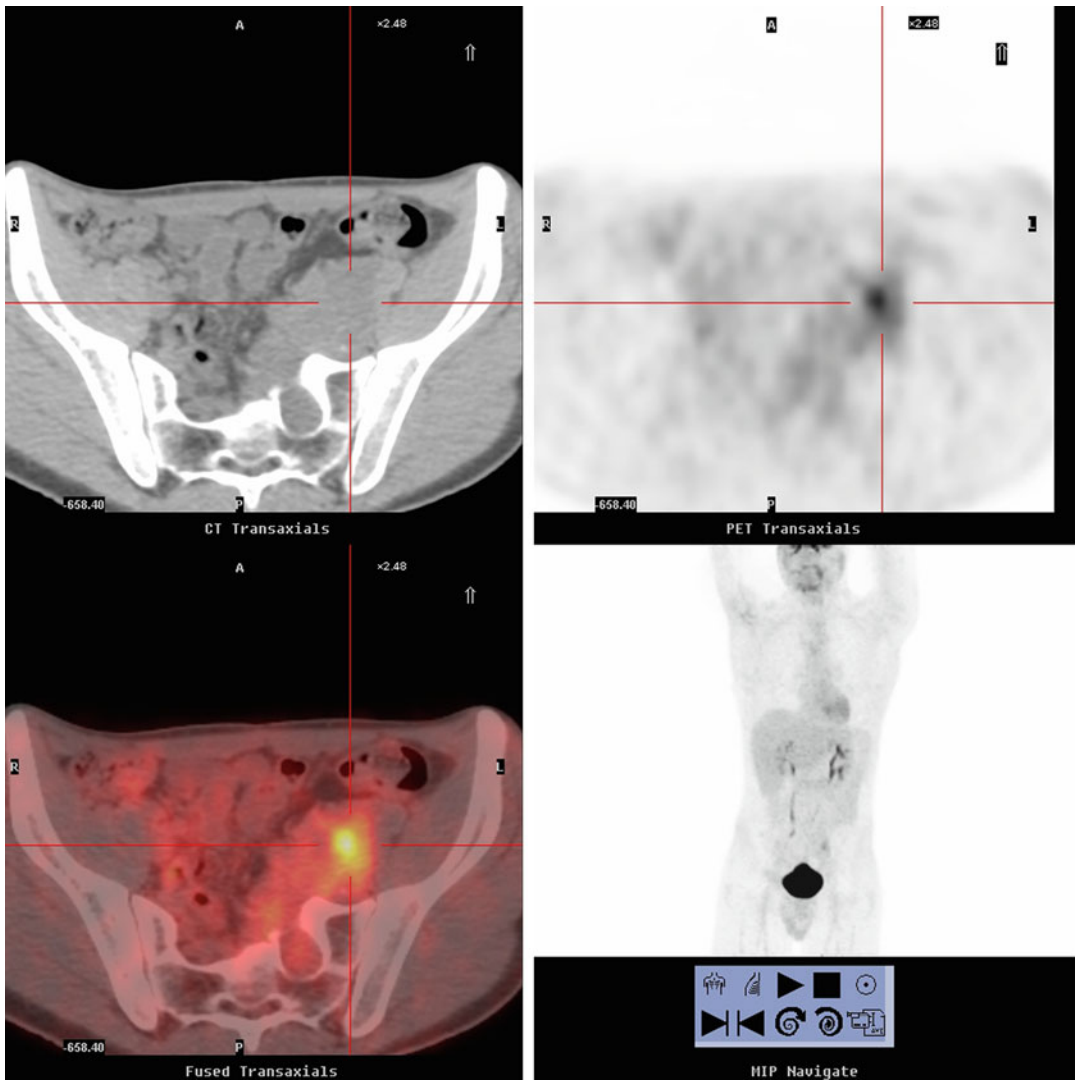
Neuroblastoma. PET/CT scan in a 17-year-old boy with a left presacral neuroblastoma (centered in the crosshairs) on localizing noncontrast CT (labeled CT
